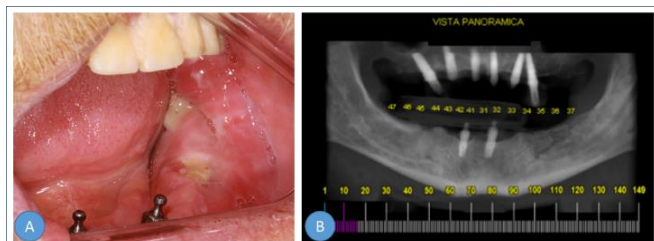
(A): Intra-oral appearance of the OMAM (Stage 3), (B): CBCT showing an area of osteolysis in the region of the left posterior mandible.
